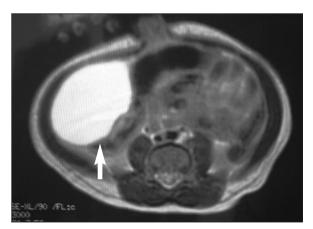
Postnatal abdominopelvic axial T1- weighted magnetic resonance imaging showing a hyperintense area 4x5 cm in diameter.
